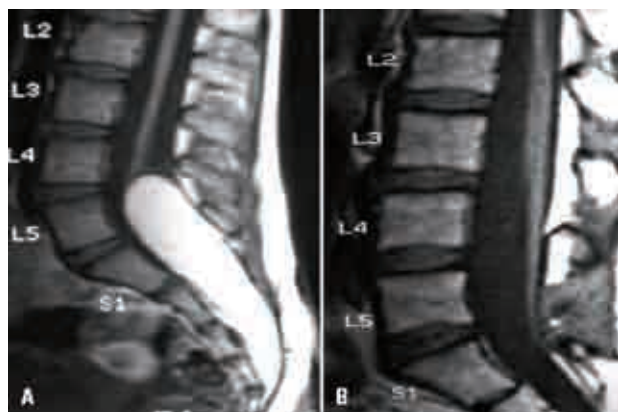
[A] T1-weighted MRI showing caudal lipoma penetrating the dura mater, with adherence to the medullary conus, which was located in an abnormally low position, and syringomyelia of the conus. [B] Surgical photograph showing a large caudal lipoma penetrating the dura mater.
